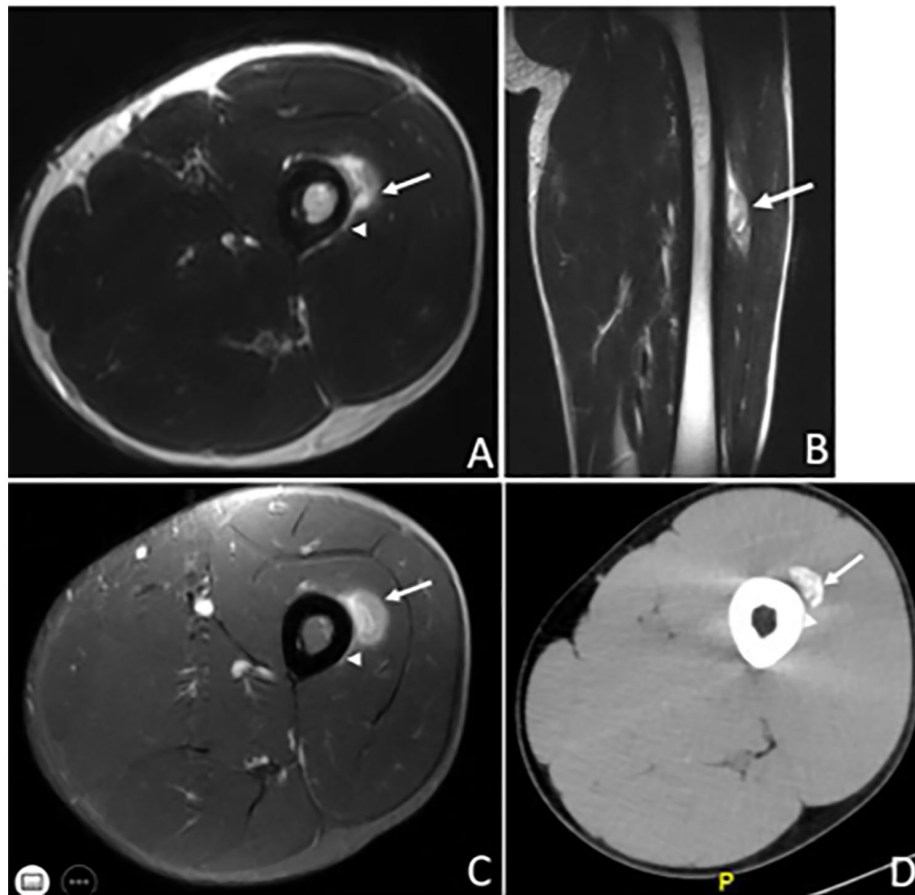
A 15-year-old male soccer player with no history of trauma and mild pain on his right thigh. The diagnosis of MO was confirmed by follow-up CT findings. (A) An axial T2w MR image demonstrates a predominately hyperintense, well-defined lesion (arrow) with hypointense foci, within the vastus intermedius muscle and in contact with femoral cortex. The bone cortex exhibits mild periosteal reaction (arrowhead) but no disruption. (B) On a sagittal T2w MR image, the lesion is oblique parallel to the muscle fibres of the vastus intermedius. (C) An axial fat-suppressed contrast-enhanced T1w MR image shows homogenous enhancement of the lesion (arrow) and mild periosteal enhancement (arrowhead). (D) Axial CT image. A diffusely calcified lesion is seen (arrow), separated from the adjacent bone cortex by a fine line (arrowhead).
